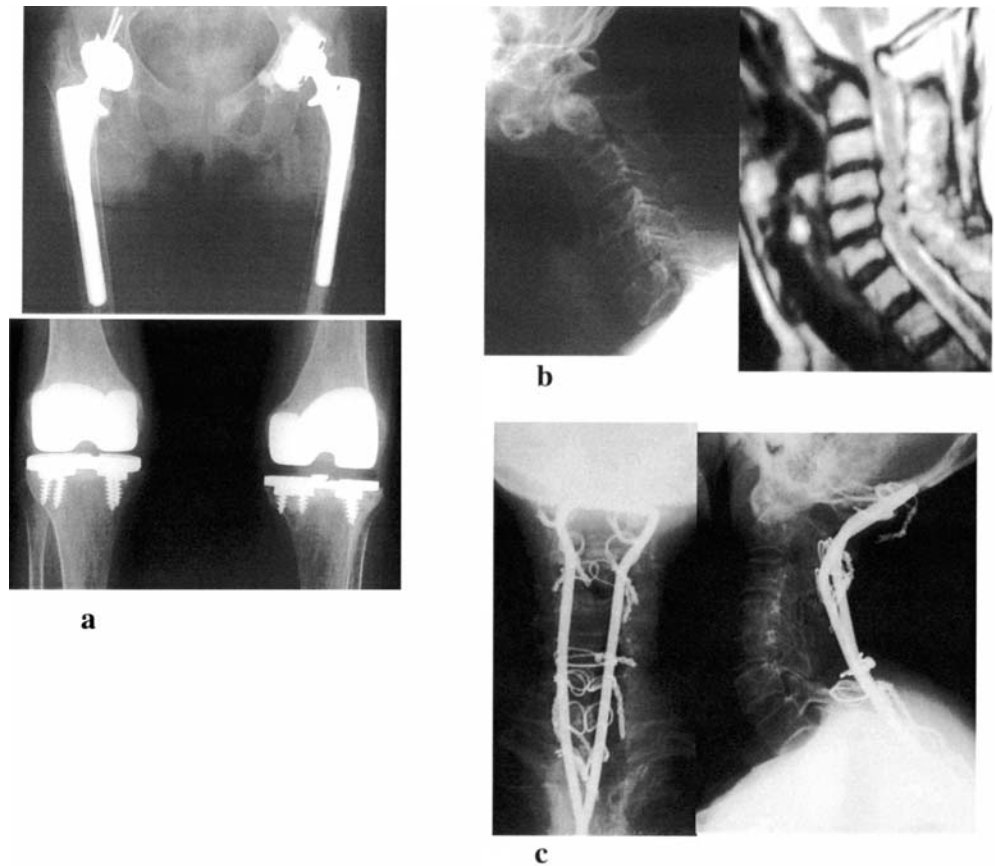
Case 5. a The patient had undergone four joint replacements (bilateral THA and bilateral TKA). b A plain lateral cervical X-ray (*left*) shows vertical subluxation and atlantoaxial subluxation, and a magnetic resonance image (*right*) shows subaxial spinal cord compression. c Decompression and spondylodesis of the occipital bone through the thoracic vertebra T4 was performed, and the X-ray image obtained 6 years after the surgery shows that the cervical vertebrae maintained stability
